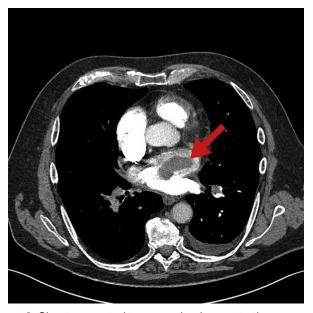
Chest computed tomography demonstrating a mass in the left atrium (*arrow*).
